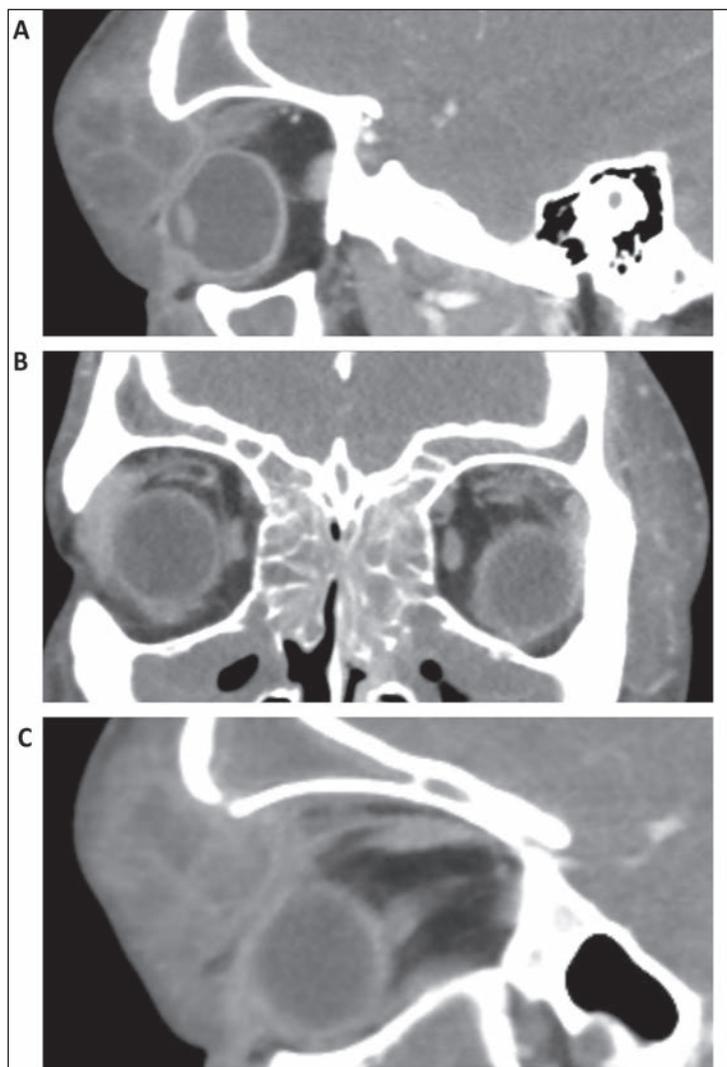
(A) Sagittal CT image on initial presentation showing a large multi-lobulated abscess with direct compression of the orbit. (B) Coronal CT image showing diffuse sinusitis of the maxillary, ethmoidal and frontal sinuses. (C) Sagittal CT image showing the frontal sinus openly communicating with one of the lobules of the orbital abscess.
